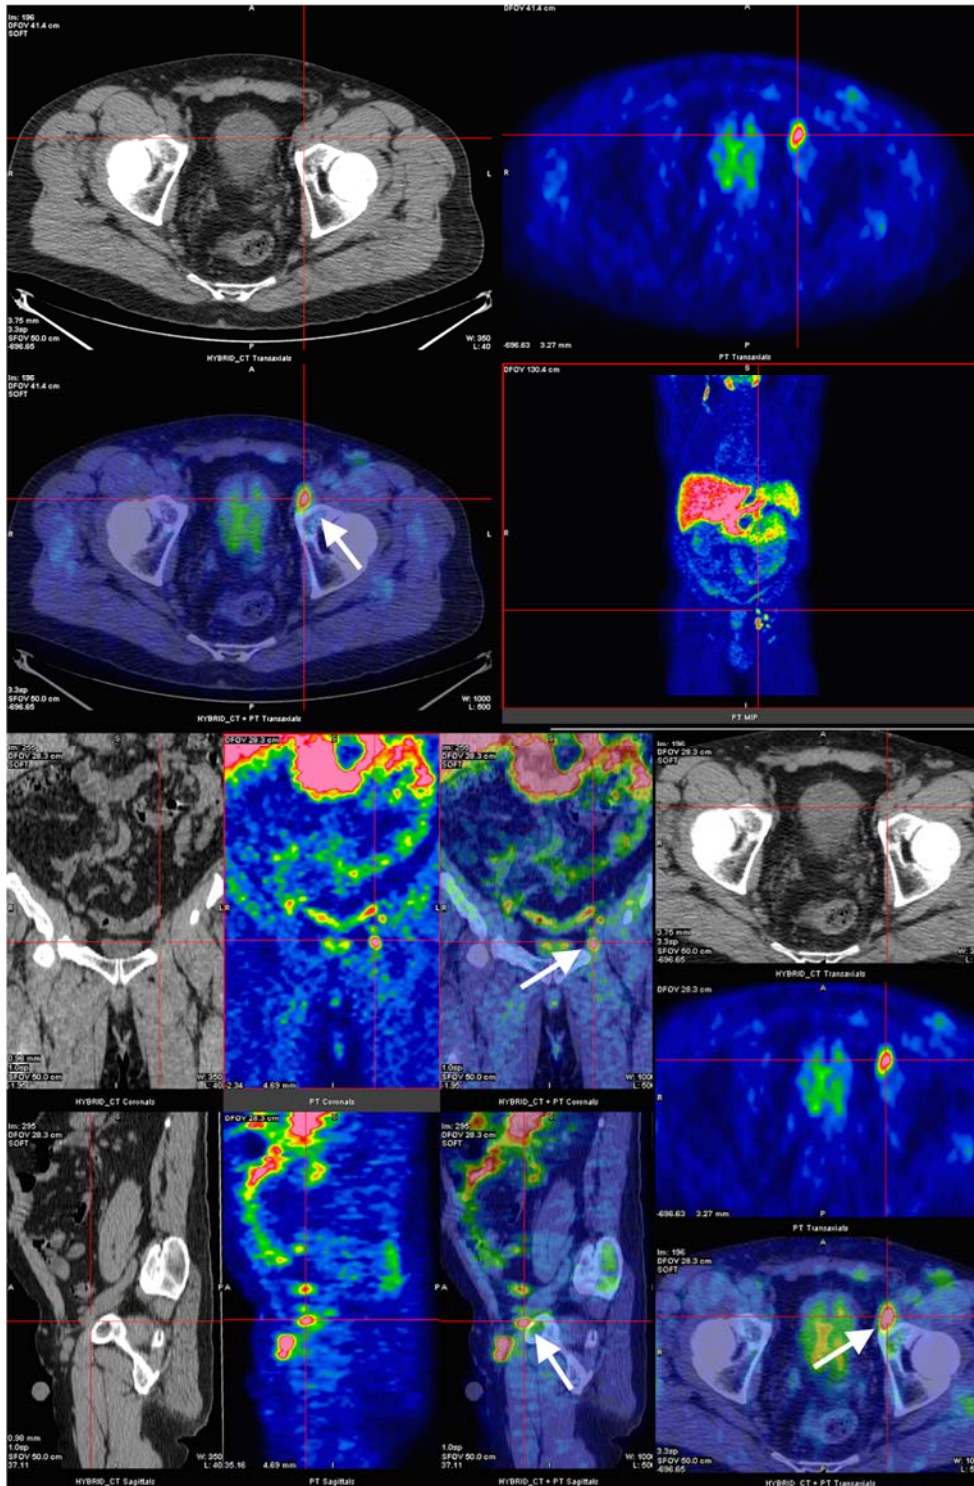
PET/CTAC images demonstrating increased ^{11}C -acetate uptake within the left external iliac chain in the node of Cloquet (white arrows) ($\text{SUV}_{\text{max}} 5.42$).
